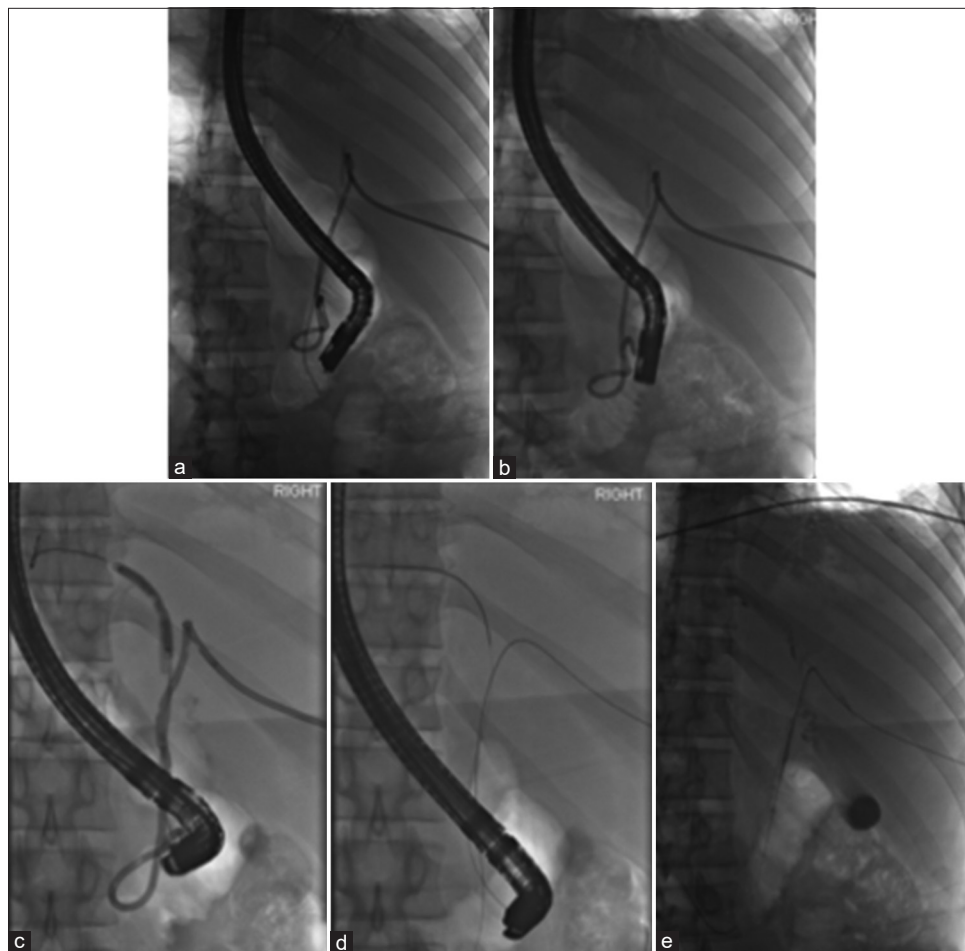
A 32-year-old male who presented with fever and abdominal pain and was found to have acute cholangitis 2 days following ERCP and left hepatic biliary stent placement. (a) Radiograph shows the distal portion of the fractured biliary stent in the CBD, while the proximal portion is seen in the LHD at time of ERC. (b) Radiograph shows the proximal portion of the fractured biliary stent in the LHD after the distal end was removed using a stent grabbing forceps. (c) Radiograph shows retrieval of the proximally migrated stent fragment with a 4 mm dilating balloon. (d) Radiograph shows successful removal of the fractured stent with the left- and right-sided wires in place. (e) Fluoroscopic image at completion of the procedure with percutaneous wire in place. ERCP: Endoscopic retrograde cholangiopancreatography, LHD: Left hepatic duct, CBD: Common bile duct.
